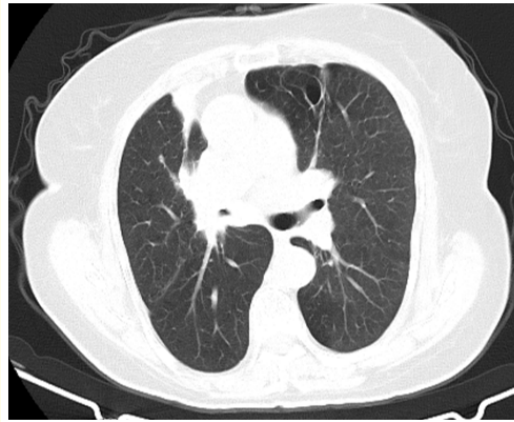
Thorax CT showing atelectasis and homogenous infiltration at the right upper lobe anterior segment.
